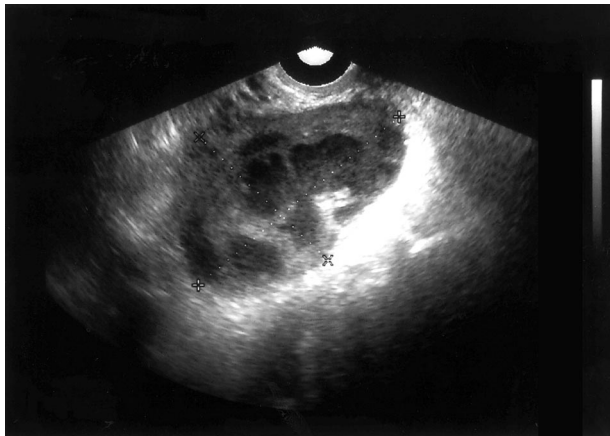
Ultrasound image of complex left adnexal mass on first day of presentation.
